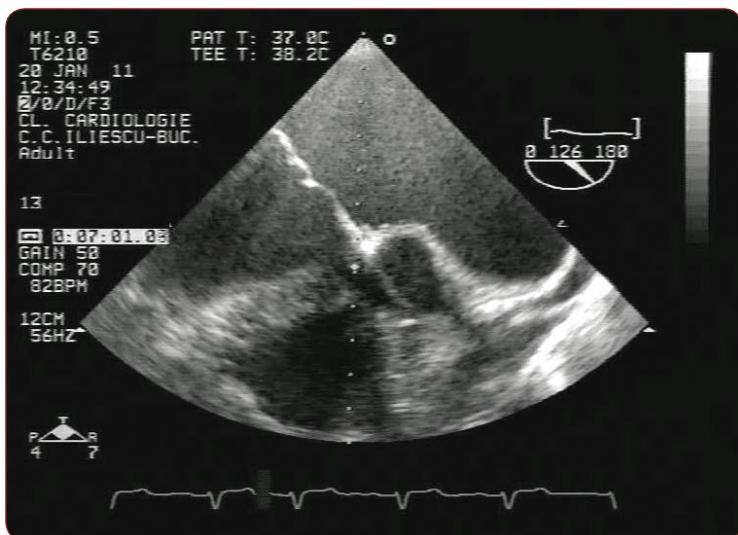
Transesophageal echocardiogram, section at 120 degrees: P₂ and A₂ prolaps.
